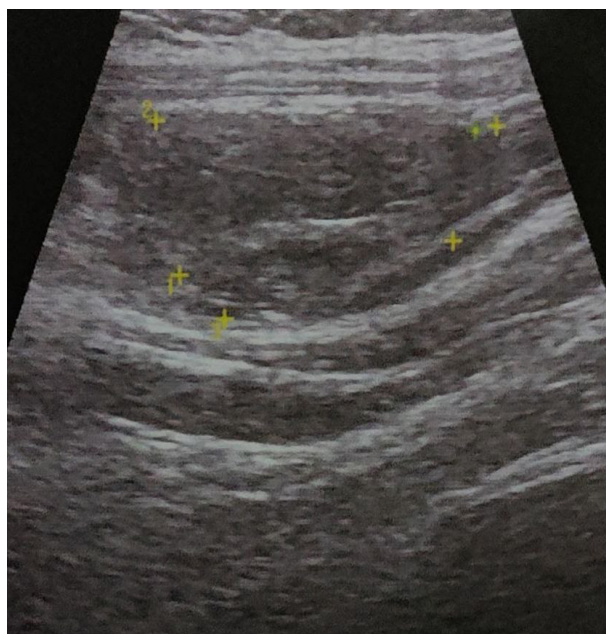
Chest wall ultrasound showing a hypoechoic area in the muscular planes of the pectoralis major muscle
